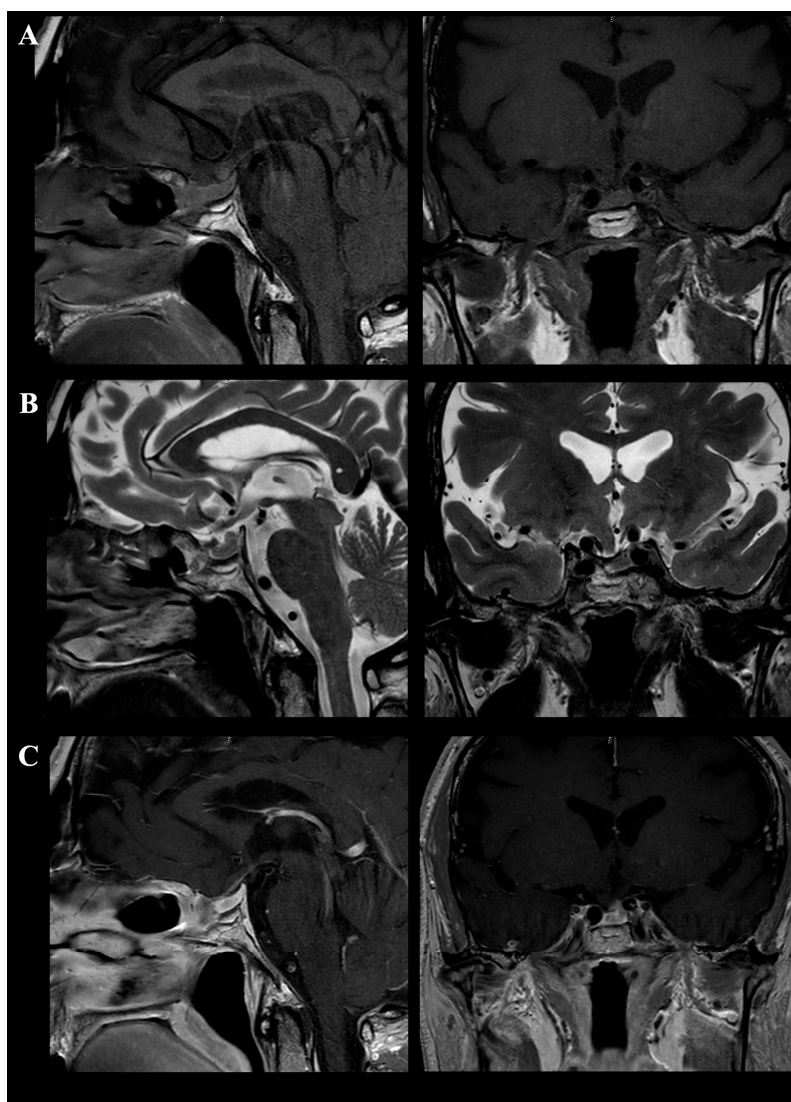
Postoperative follow-up magnetic resonance imaging at 1 year. Sagittal and coronal T1-weighted images (A) and T2-weighted images (B) demonstrate no evidence of local tumor recurrence. Contrast-enhanced sagittal and coronal T1-weighted images (C) reveal a small (3 × 2 mm) nodular enhancing focus at the operative site without interval progression.
